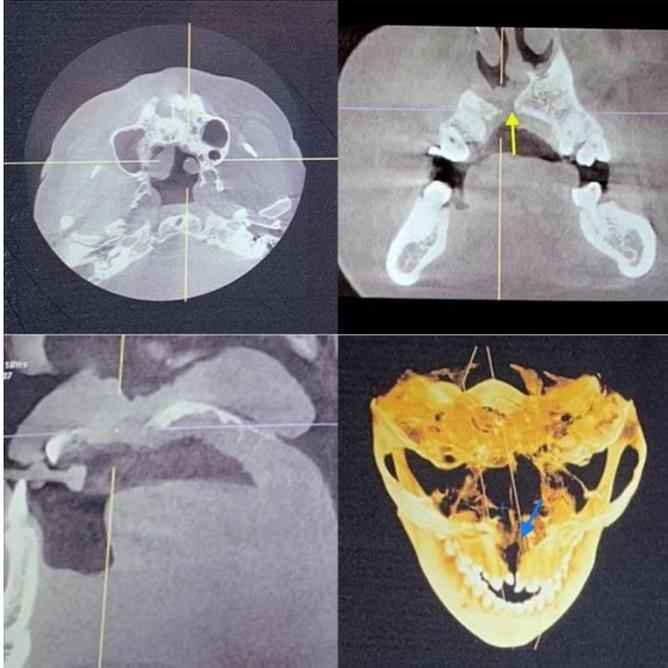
CBCT scan of Maxillofacial region
